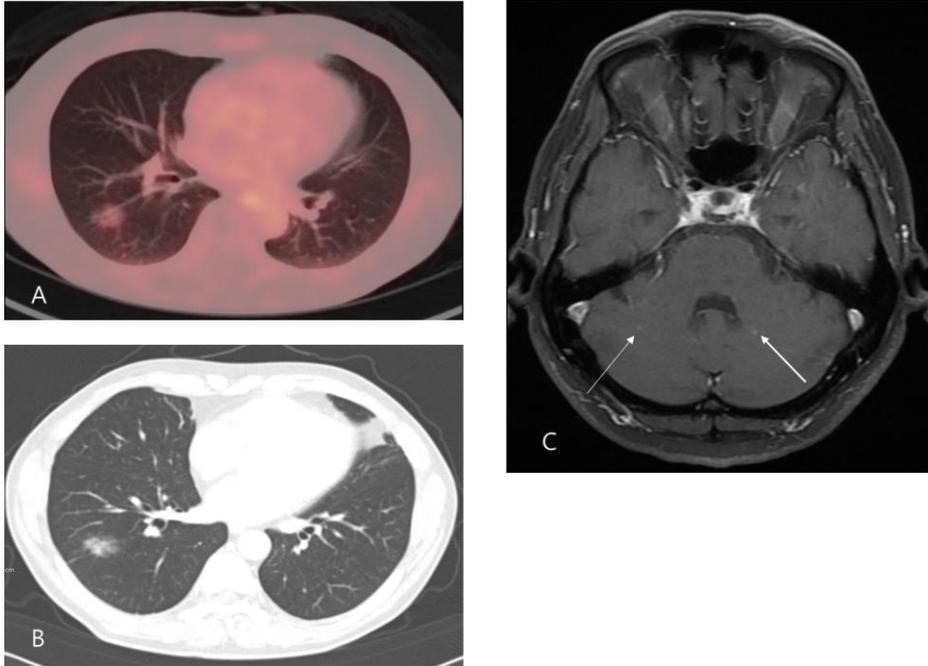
Representative case of a silent brain metastasis in Stage 1A on both chest CT and F-18 FDG PET/CT. A male patient of 64-year old was diagnosed with right lower lobe lung adenocarcinoma. Chest computed tomography (CT) showed pulmonary nodule measuring 2.5cm part solid nodule in the right lung lower lobe with no mediastinal lymph node enlargement (T1b N0 M0) (B). PET/CT demonstrated mild hypermetabolism of the nodule in the right lower lung lobe (SUVmax 1.32) with no other abnormal metabolism (T1b N0 M0) (stage IA; According to the AJCC staging system 7th edition) (A). Axial T1-weighted post contrast MRI showed two tiny enhancing nodules in both cerebellar hemisphere, left one with mild perilesional edema which considered as brain metastasis (C).
